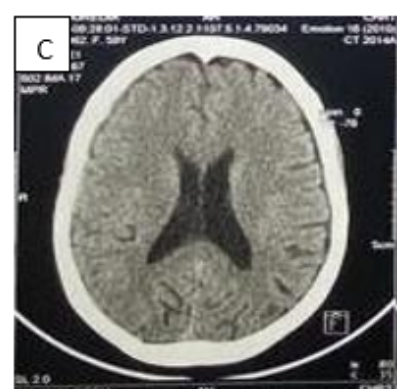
Cerebral CT scan without contrast injection at 3 months of corticosteroid therapy complete resorption of the hematoma.
